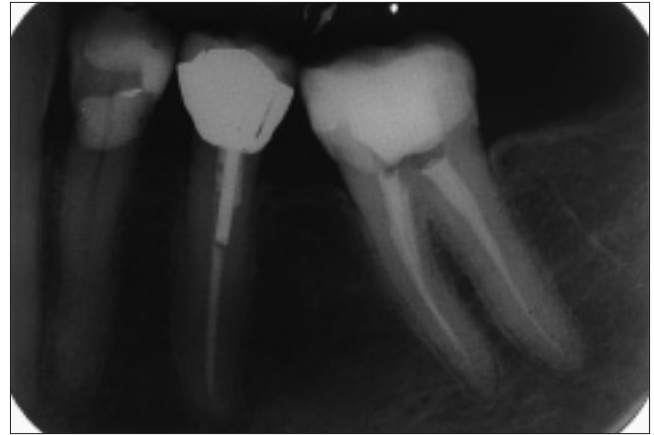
Postoperative radiograph of tooth 36 root canal treatment.
